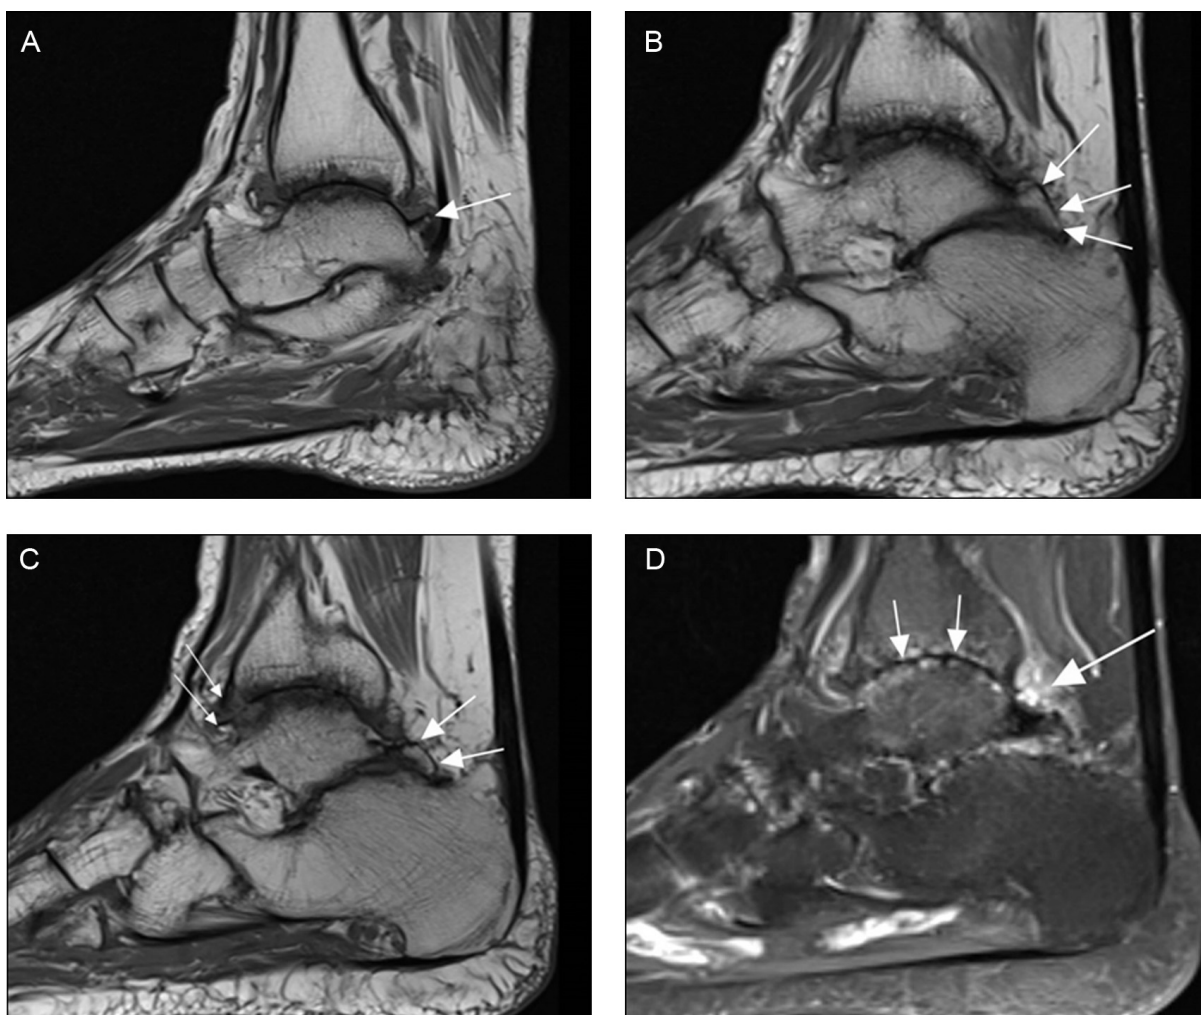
A 58-year-old male active runner with advanced post-traumatic osteoarthritis of the ankle joint and posterior pain. (A) Sagittal T1-weighted MRI shows advanced osteoarthritis of the tibio-talar joint and a large posterior talar osteophyte that impinges into the posterior joint capsule especially on plantar flexion (arrow). (B) An additional large osteophyte is seen at the posterior margin of the talus leading to impingement at the calcaneo-talar joint (arrow). (C) The osteophyte reaches far laterally (large arrows) and in addition anterior tibiotalar osteophytes are observed (small arrows). (D) Sagittal contrast enhanced T1-weighted fat-suppressed MRI shows that reactive synovitis is primarily observed posteriorly (large arrow), which correlates well with the clinical picture. There is complete obliteration of the tibiotalar joint (small arrow).
